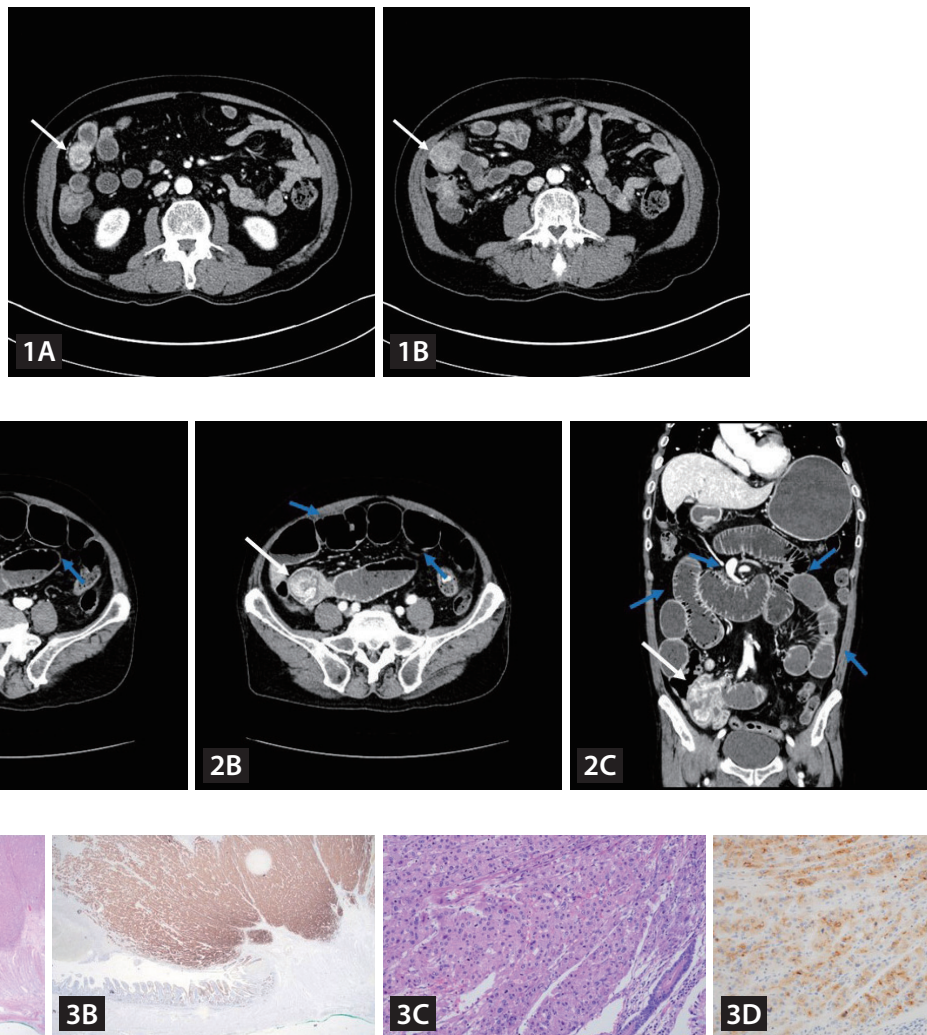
Computed tomography (CT) imaging. (A, B) Contrast-enhanced CT showed polypoid enhancing masses (white arrow) in the distal ileum.
